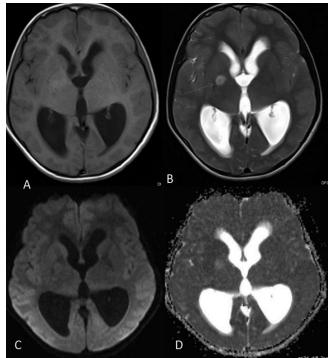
MRI brain showing hamartoma in right globus pallidus appearing isointense on T1WI (A), hyperintense on T2WI (B), not showing restriction on DWI(C,D).
